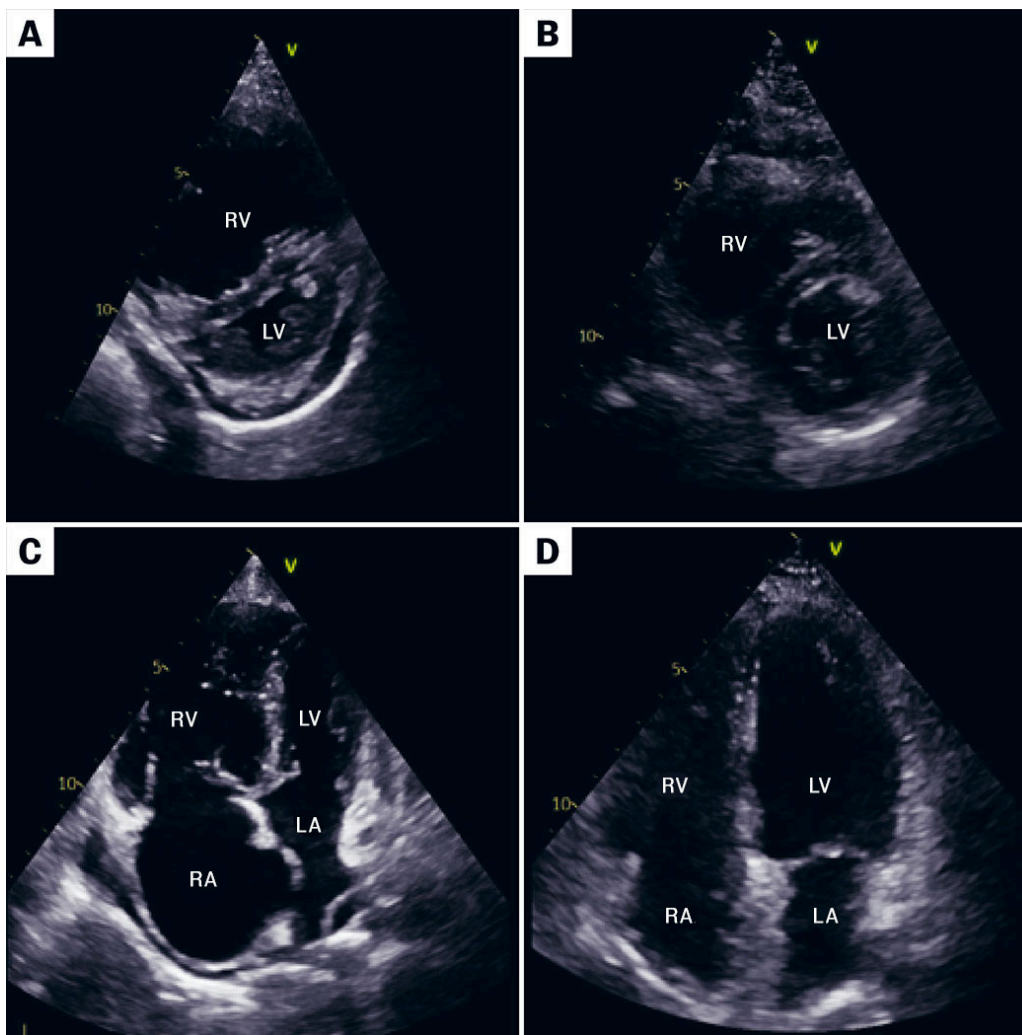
Panels A and B show echocardiography from the parasternal short axis view before and after pulmonary endarterectomy. The pre-surgery image (A) demonstrates pressure overload of the right ventricle (RV), with curving of the interventricular septum towards the left ventricle (LV). The post-surgery image (B) demonstrates normalisation of the septal shape. Panels C and D show echocardiography from the same patient in an apical 4 chamber view before and after surgery. The pre-surgery image (C) demonstrates a severely dilated right ventricle, which is normalised after surgery (D). LA = left atrium, RA = right atrium.
